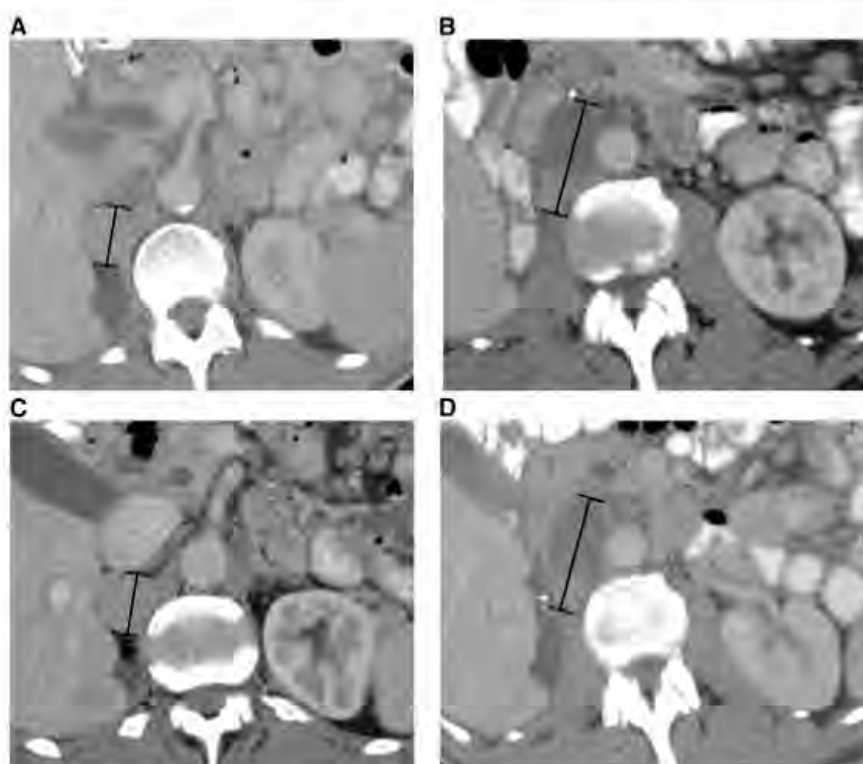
A 73-year-old man with metastatic renal cell carcinoma treated with foretinib. Axial contrast-enhanced computed tomography (CT) images at baseline (A and B) demonstrate target right adrenal and retroperitoneal metastases (black measurement lines), measuring 31 mm and 58 mm in long axis, respectively. Axial contrast-enhanced CT at first follow-up after treatment initiation (C and D) demonstrates approximately 10% decrease in the sum of the longest diameter of the targets (black measurement lines), measuring 28 mm and 52 mm, respectively.
